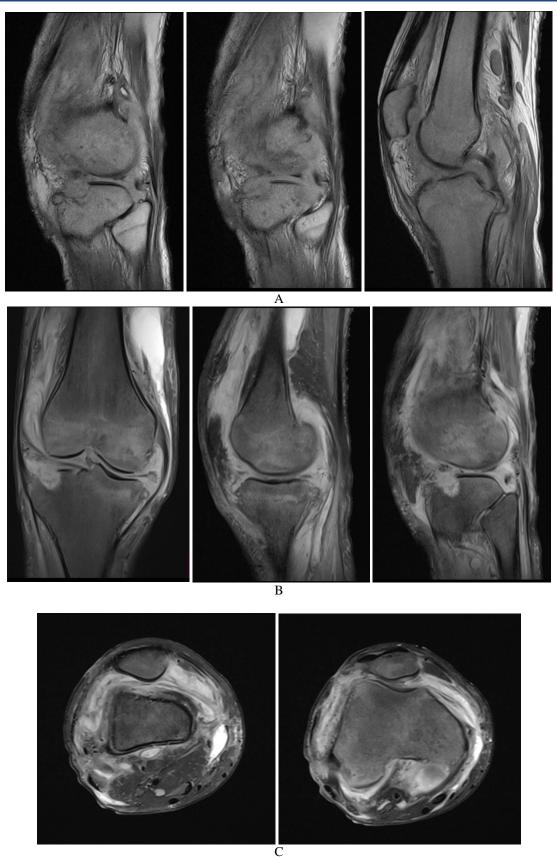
A). MRI of the knee: A. Sagittal sequence T1: showing geode of the external tibial 1plateau (white star), cartilage lysis. B). Sagittal and coronal DP FAT SAT sequences showing important synovial thickening, popliteal lymph node. C). Axial T2 sequence showing important synovial thickening
